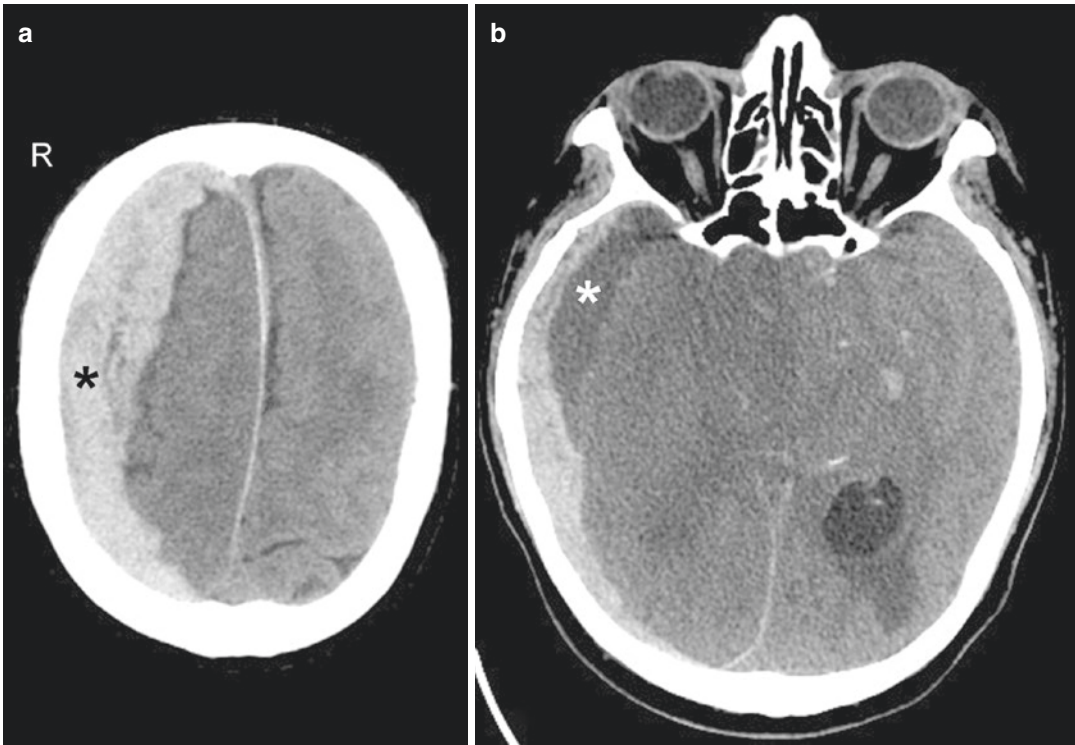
SDH. (a) Non-contrast axial CT image demonstrates a right hyperdense, holo-hemispheric extra-axial collection (*asterisk*), causing mass effect and sulcal effacement of the right cerebral hemisphere. There is also mild right-to-left subfalcine herniation. (b) Non-contrast axial CT image shows a low-density area (*asterisk*) corresponding to a chronic SDH component within an acute
